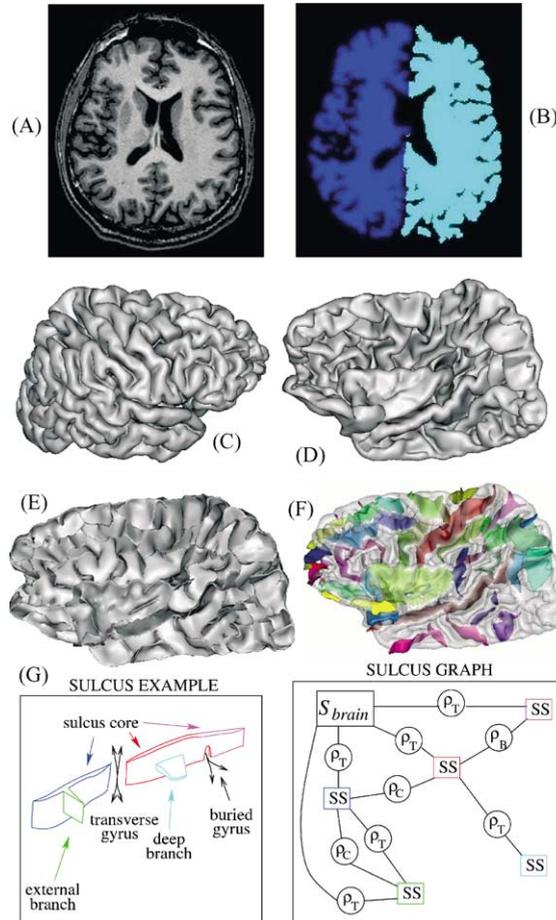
Computation of a structural representation of the cortical folds from a raw T1-weighted MR image [41,58]: (A) raw MR slice; (B) brain hemisphere segmentation; (C) right hemisphere cortex external surface; (D) right hemisphere cortex inner surface (interface between grey and white matters); (E) skeleton of the (cortex + cerebro spinal fluid) object; (F) segmentation of the skeleton using discrete topology and labelling of the main sulci with colors (several folds can be gathered in the same sulcus); (G) an example of the attributed subgraph representing a sulcus. Each node SS is a piece of the surfacic skeleton while  $S_{brain}$  represents the brain hull. Three kinds of relations are used: topological junction  $\rho_T$ , neighbor geodesic to the brain hull  $\rho_C$ , split induced by a buried gyrus  $\rho_B$ . Semantic attributes like size, length, depth, etc. are added to nodes and relations for recognition purpose.
